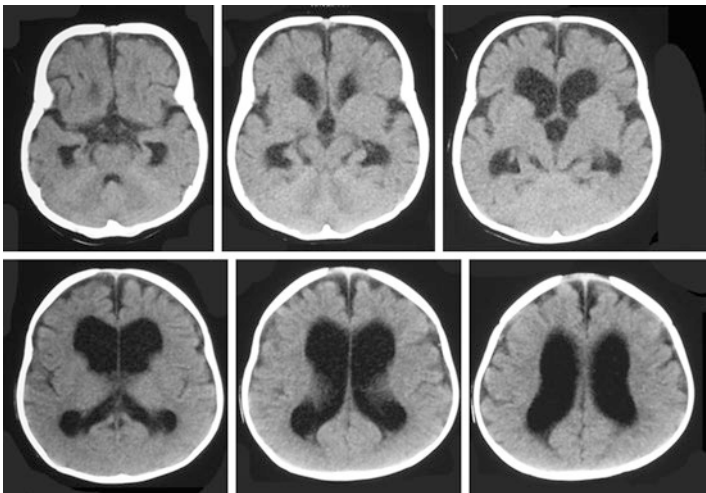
Non-contrast brain CT scan of an infant showing enlarged ventricles and prominent sulci suggesting some degree of cerebral atrophy. Note in particular that the subarachnoid spaces in the Sylvian fissures and over the frontal lobes are readily seen (compare with Fig. 4.8)
